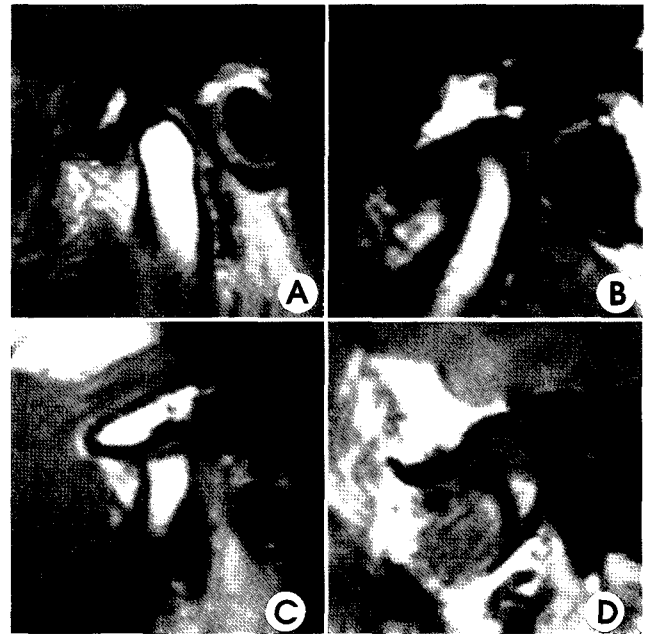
MR images show osseous changes of the condylar head (A: sclerosis, B: flattening, C: erosion, D: osteophyte formation).
